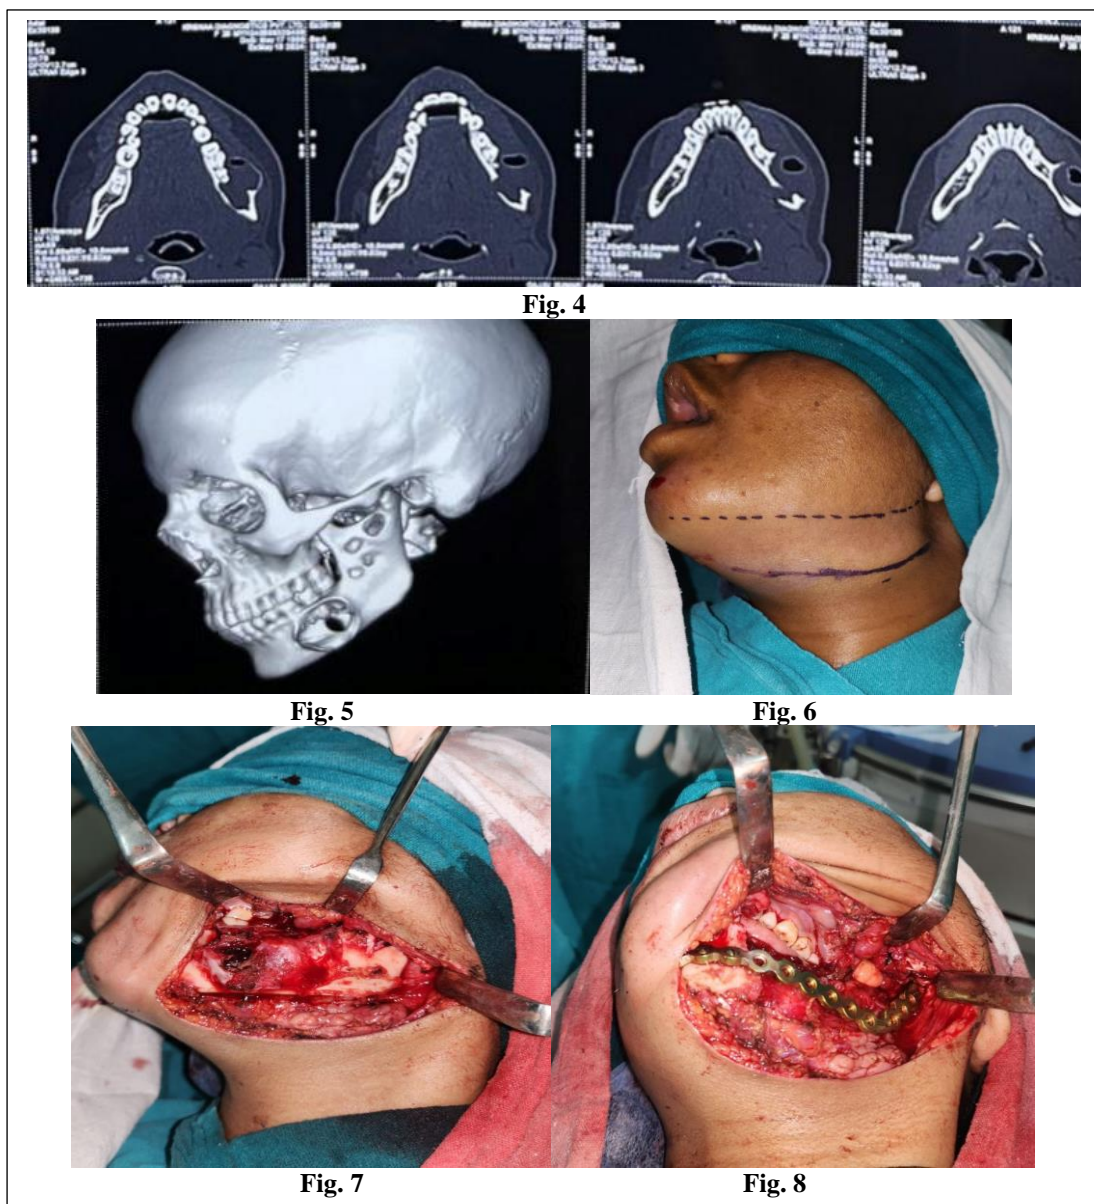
axial section of CT, Fig. 5 3DCT showing all erupted teeth, Fig. 6 incision marking, Fig. 7 exposure of lesion, fig. 8 reconstruction with recon plate.
